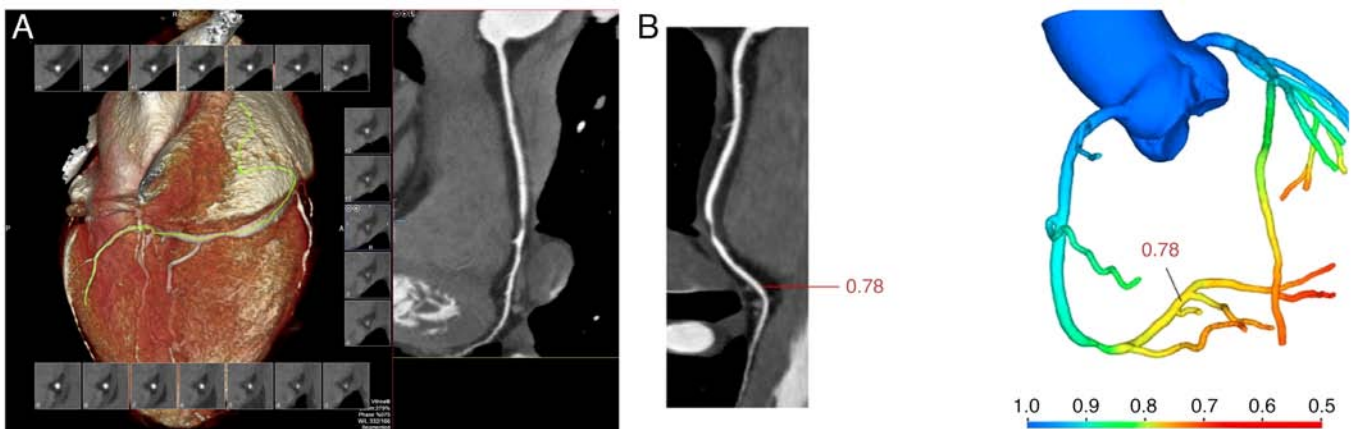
CCTA and CT-FFR of a male, 67-year-old patient. (A) The CCTA revealed a hypodense plaque with severe luminal stenosis at the second turn of the right coronary artery. (B) The CT-FFR value measured at the distal end of the plaque was 0.78. CCTA, coronary computed tomography angiography; CT-FFR, computed tomography-derived fractional flow reserve.
